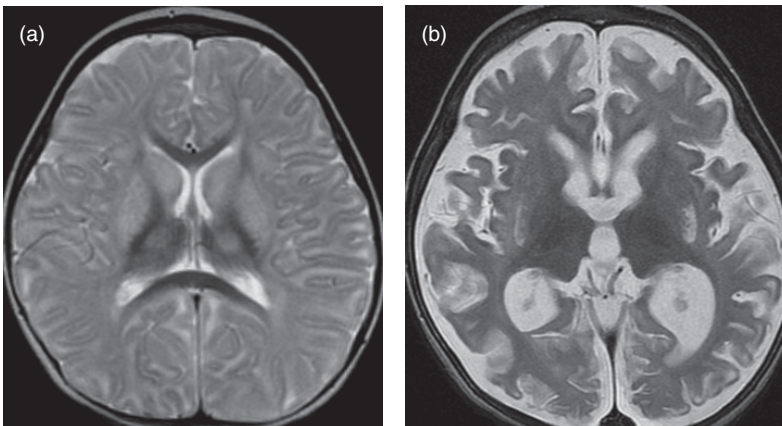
Hypoxic ischemic injury in an 11-month-old infant with carbon monoxide poisoning and cardiac arrest. (a) Axial T2 image from the admission MRI demonstrates extensive deep gray matter and diffuse hemispheric signal T2 prolongation. (b) At a six-month follow up, there is evolution to extensive deep and cortical gray matter encephalomalacia.
